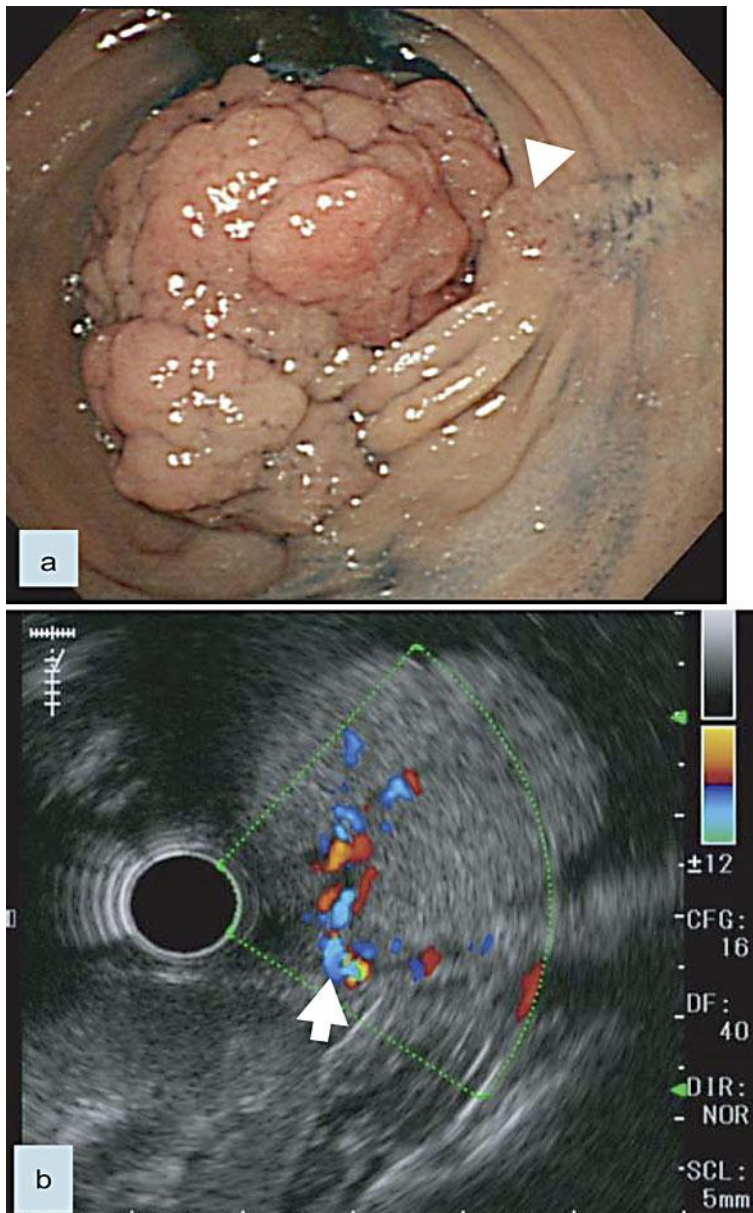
a Upper gastrointestinal endoscopy findings show an elevated red and finely granular lesion from the oral side of the ampulla of Vater (arrowhead). b Endoscopic ultrasonography shows a highly vascularized tumor originating from the mucosa (arrow: feeding artery and drainage vessels).
